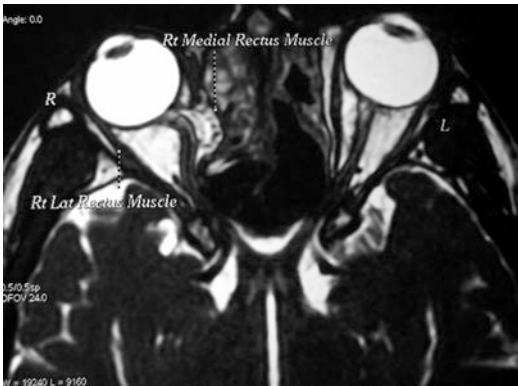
T2-weighted axial MRI image of transected right medial rectus (RMR) in the same patient (Figure reprinted with permission from © Association of Otolaryngologists of India 2015)
